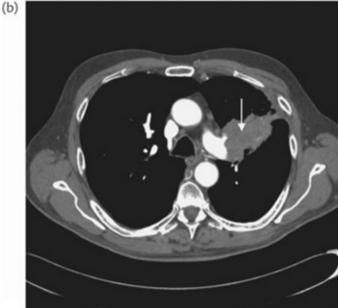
(a) Chest radiograph showing an ill-defined parenchymal mass (arrow) in the left upper lobe; (b): CT scan of the chest of the same patient as in (a), confirming a large central mass (arrow) encasing the left upper lobe bronchus.
